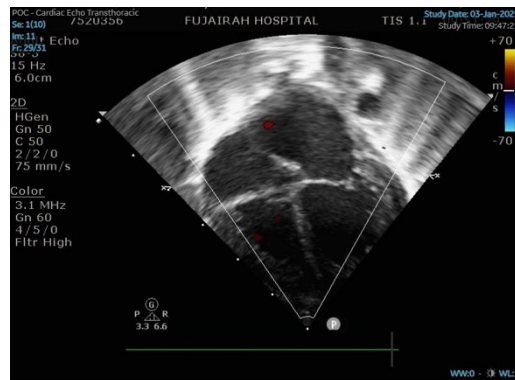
Apical 4 chambers view reveals LA and LV dilation.
